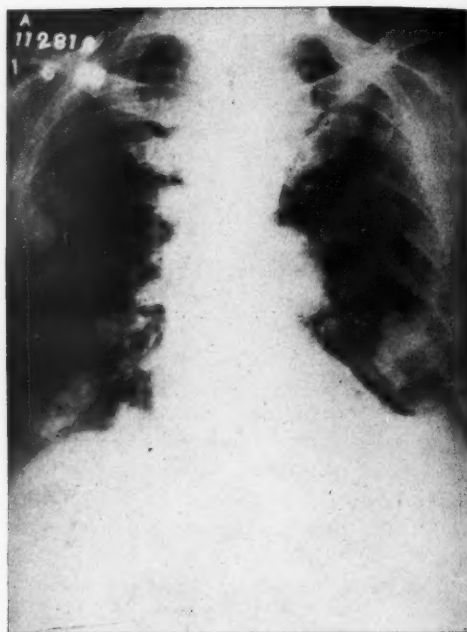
Case 2. Roentgenogram of chest, showing multiple areas of metastases in lungs and small amount of fluid at the left base.
